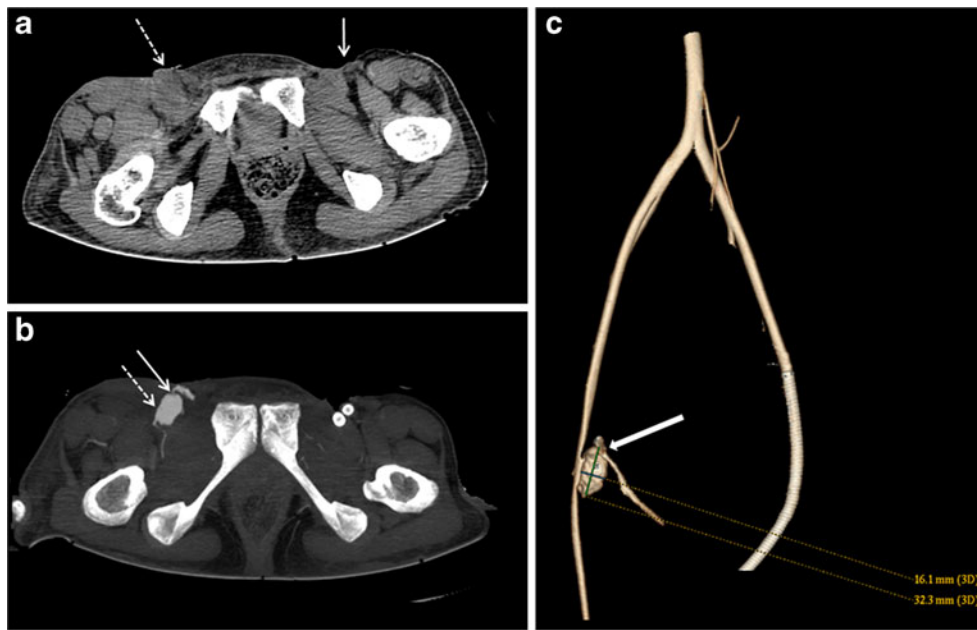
Radiological images. a Native CT revealed the presence of subcutaneous infiltrations in both inguinal regions (*arrows*), essentially on the left side (*dotted arrow*). b Maximum intensity projection reconstructed after an arterial phase of MPMCTA showing a pseudo-aneurysm filled with contrast agent (*dotted arrow*) in the right inguinal region.
